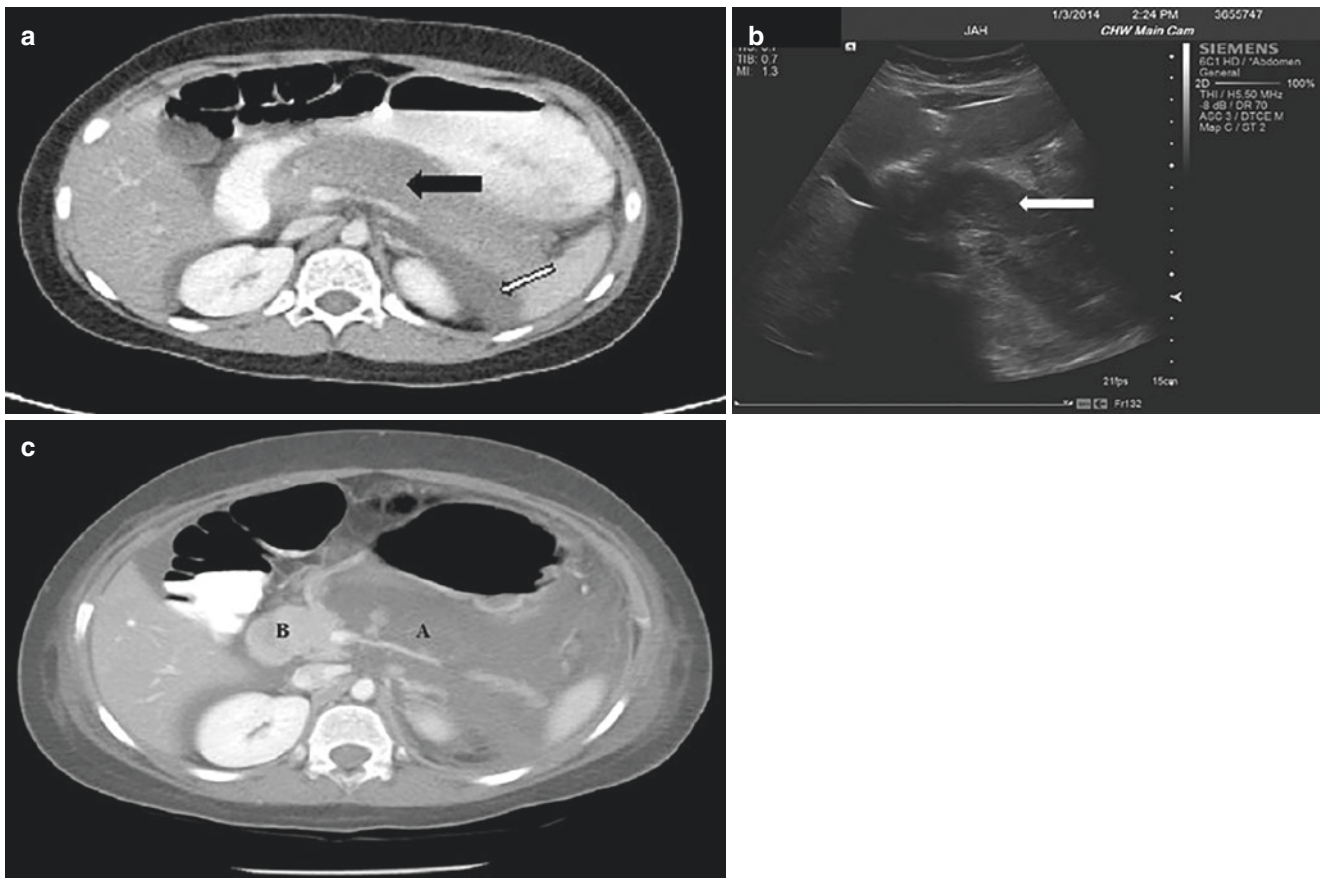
MRCP changes in chronic pancreatitis. (a) Early acute pancreatitis. Note edematous gland (black arrow) with a small amount of fluid (small arrow). No visible ducts or calcifications. (b) Ultrasound of the same patient showing a hypoechoic and edematous pancreas
